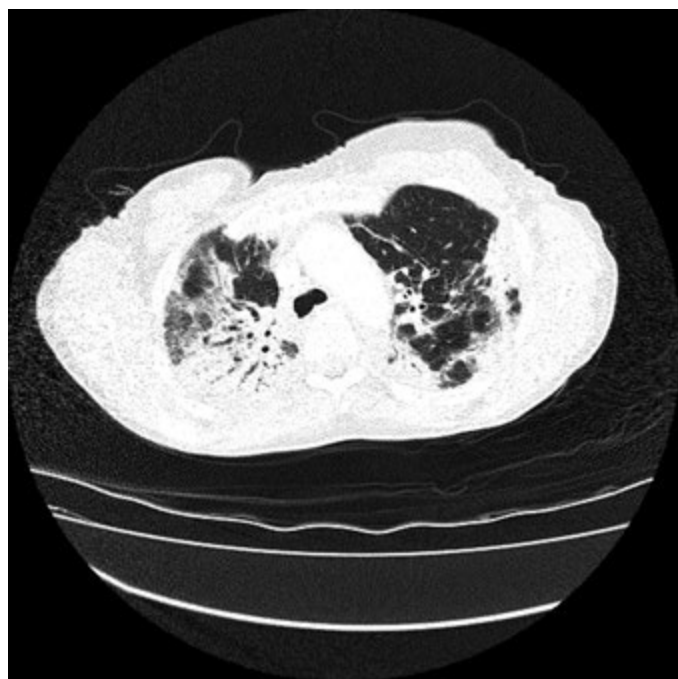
Eosinophilic pneumonia due to dapson. CT shows extensive patchy air space opacification in the upper lobes with subpleural predominance. Bronchoalveolar lavage showed eosinophilia and no infection. Blood eosinophil count was elevated at $1.43 \times 10^9/\text{litre}$ (0.04–0.4).
